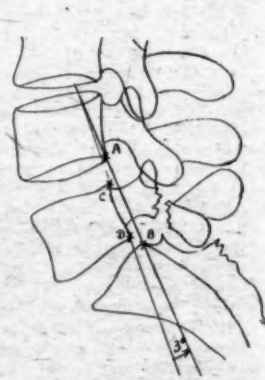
Tracing of a radiograph revealing a condition within normal limits, but "borderline" spondylolisthesis may be present; the lines drawn in such cases rarely intersect above the fifth lumbar vertebra, but normally form an angle which has never exceeded 3°.
